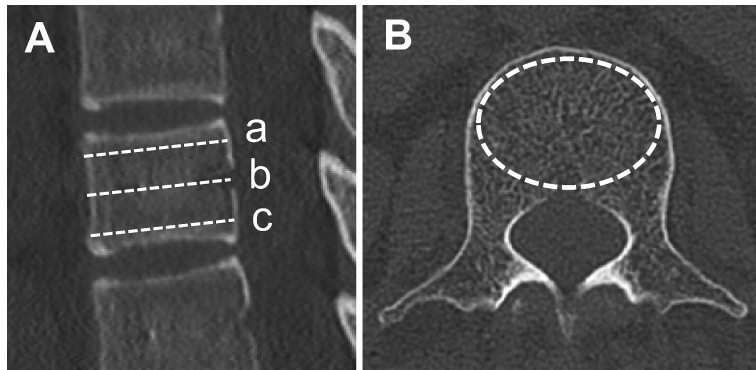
Measurement points for CT values in vertebrae adjacent to the fractured vertebral body
